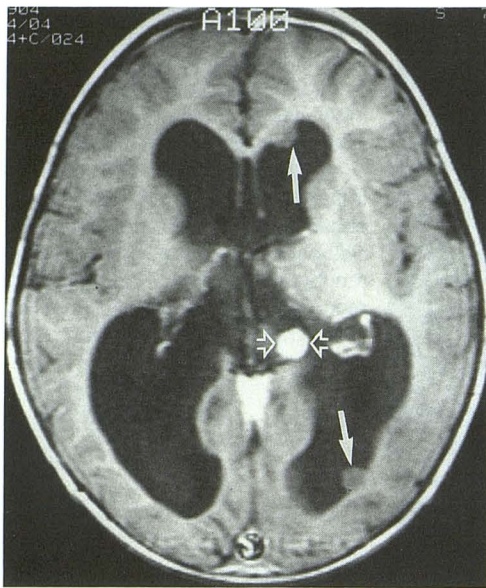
MR image of a 2-year-old boy obtained 7 months after surgery. Enhanced short-TR (500/20) axial MR image shows nonenhancing (solid arrows) and enhancing (open arrows) intraventricular metastases.
